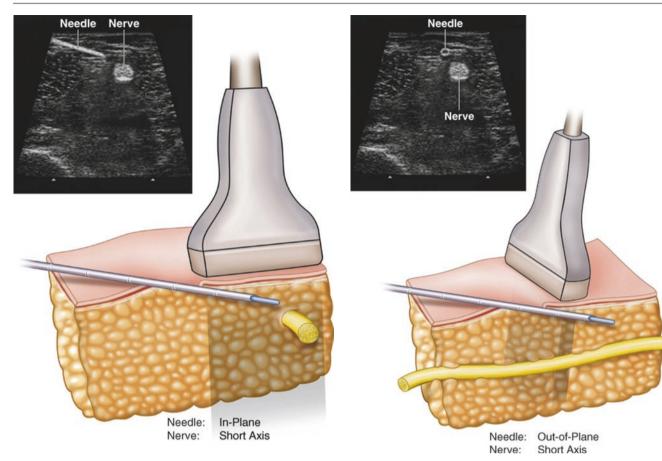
Short-axis imaging of the target nerve with needle advancement under in-plane ultrasound guidance
